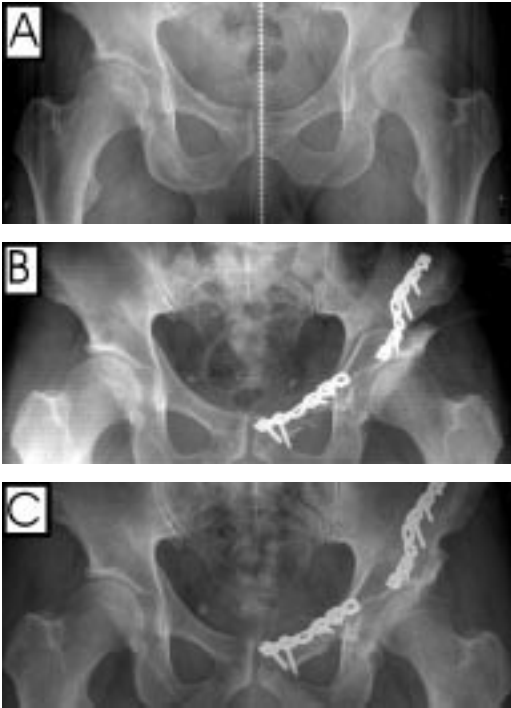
Radiographs taken preoperatively, postoperatively and at latest follow-up of a 43-year-old male patient with dysplasia of the left acetabulum, who had pain in his hip for several years (patient no. 5 in Table 1).
